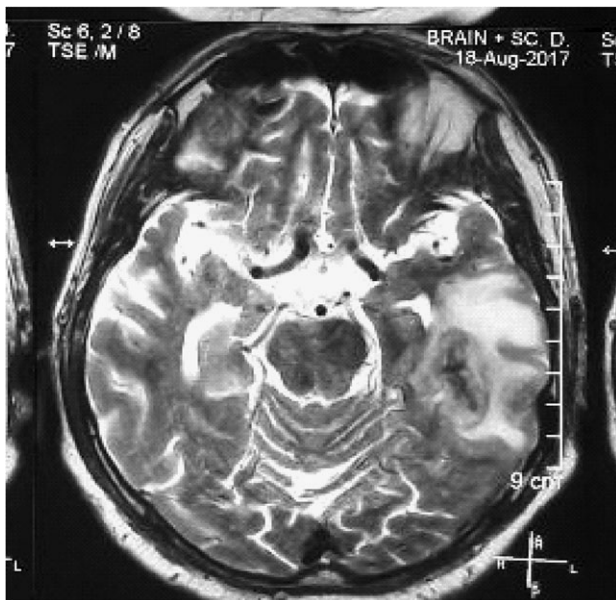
MRI at presentation: T2 hyper intense lesion at left temporal lobe with minimal enhancement and small bleeding areas consistent with hemorrhagic encephalitis.
